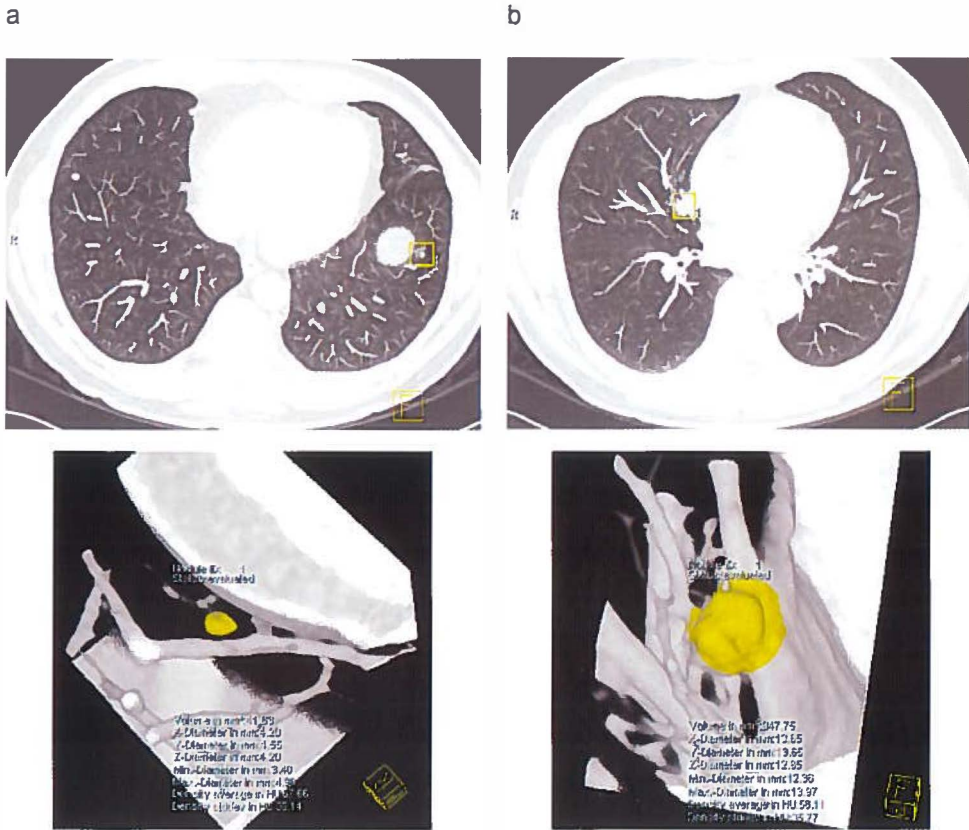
Example of initial segmentation of a lung nodule in 2 screening participants. Low-dose, non-contrast medium enhanced CT of the thorax. Display as maximum-intensity projection (MIP) transverse section (upper images), and as volume rendered image (lower images), both within software package P₁. Satisfactory initial segmentation (a). Unsatisfactory initial segmentation (b).
